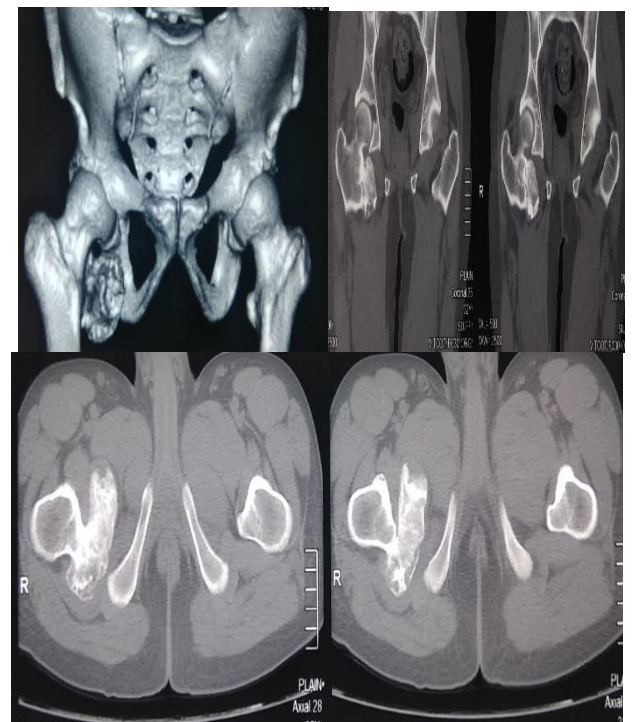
CT scan showing continuity of cortex and medulla between the tumour and the parent bone. (pathognomonic sign in osteochondroma).
